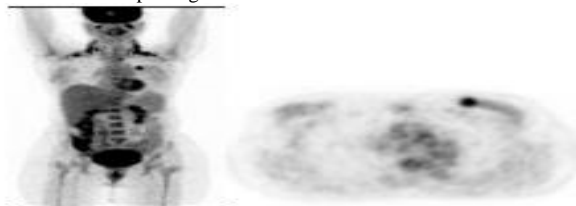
PET Maximum intensity projection (MIP) and axial PET thorax showing a FDG avid mass which was tumor stage II and TNM stage II left breast invasive ductal carcinoma. The pSUVmax of the primary tumor was 7.5. It was ER and PR positive and negative for Her2/Neu receptor. Note is made of incidental uptake in brown fat in the neck on bothsides.
